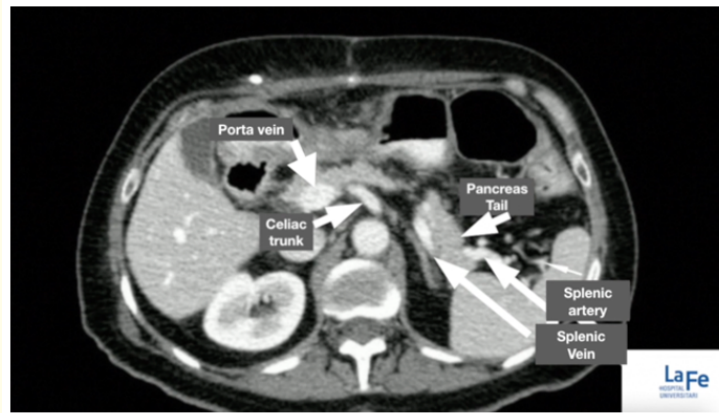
Splenic artery and vein anatomy in CT.
